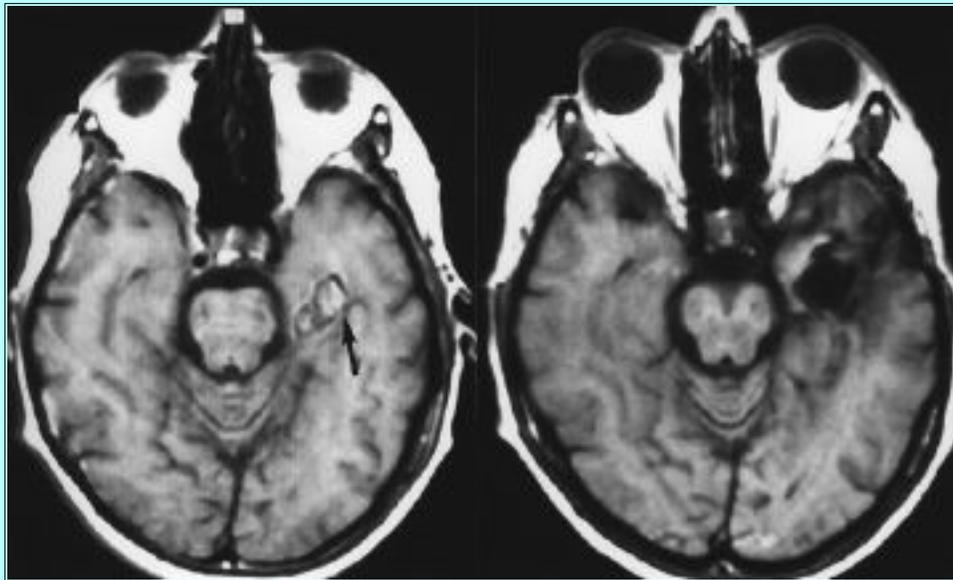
Case 1. Left: Preoperative axial magnetic resonance (MR) image (TR 500 msec; TE 7 msec) showing two adjacent lesions (arrow) in the parahippocampal gyrus characterized by focal central heterogeneity and a circumferential ring of iron-storage forms. Right: Postoperative MR image showing complete removal of both lesions.
